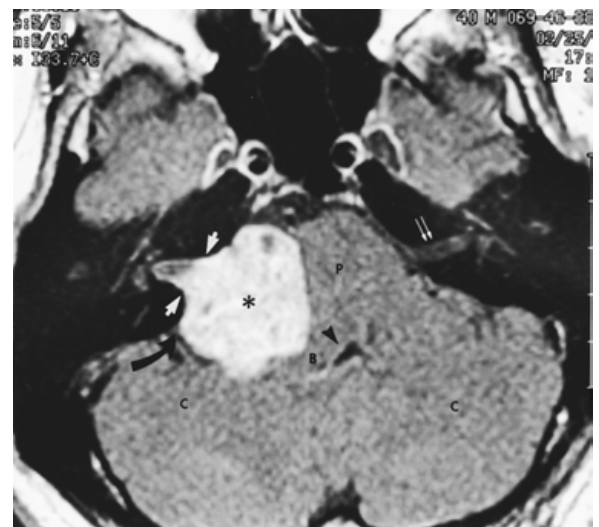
Acoustic neuroma. Axial T1-weighted magnetic resonance imaging following intravenous contrast injection. There is a bulky, enhancing mass lesion (asterisk) in the right cerebellopontine angle (CPA), internal auditory canal (IAC), and a widened porus acusticus (arrows). It extends ~1 cm into the IAC; the 3 cm cisternal component has compressed the pons (P), brachium pontis or middle cerebellar peduncle (B), and cerebellar hemisphere (C) with partial effacement and distortion of the fourth ventricle (arrowhead). The lesion makes an acute angle with the petrous bone (curved arrow). Note the normal IAC and porus on the left side (double arrows).
